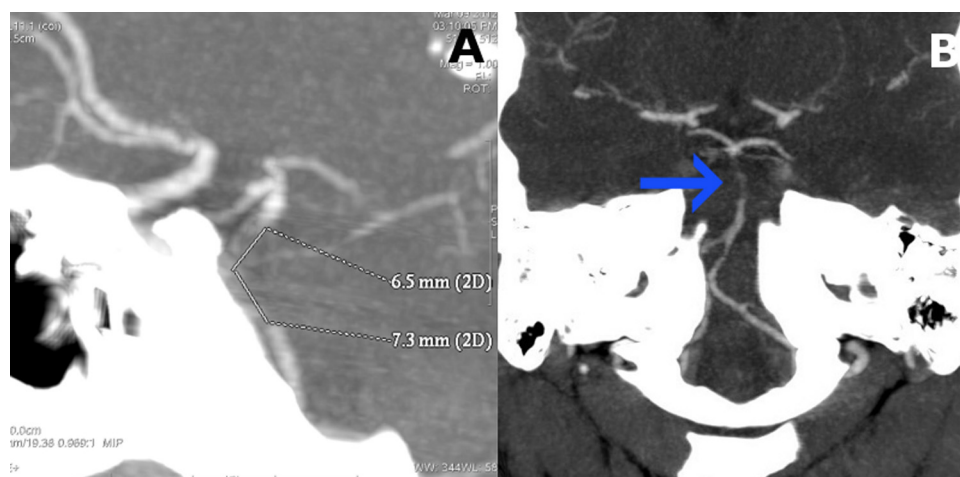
Computed tomography angiography (CTA). (A) No contrast enhancement in upper segment of the basilar artery, over the length of ca. 13.8 mm. (B) This points to a basilar artery occlusion or critical stenosis due to thrombosis (arrowhead).
